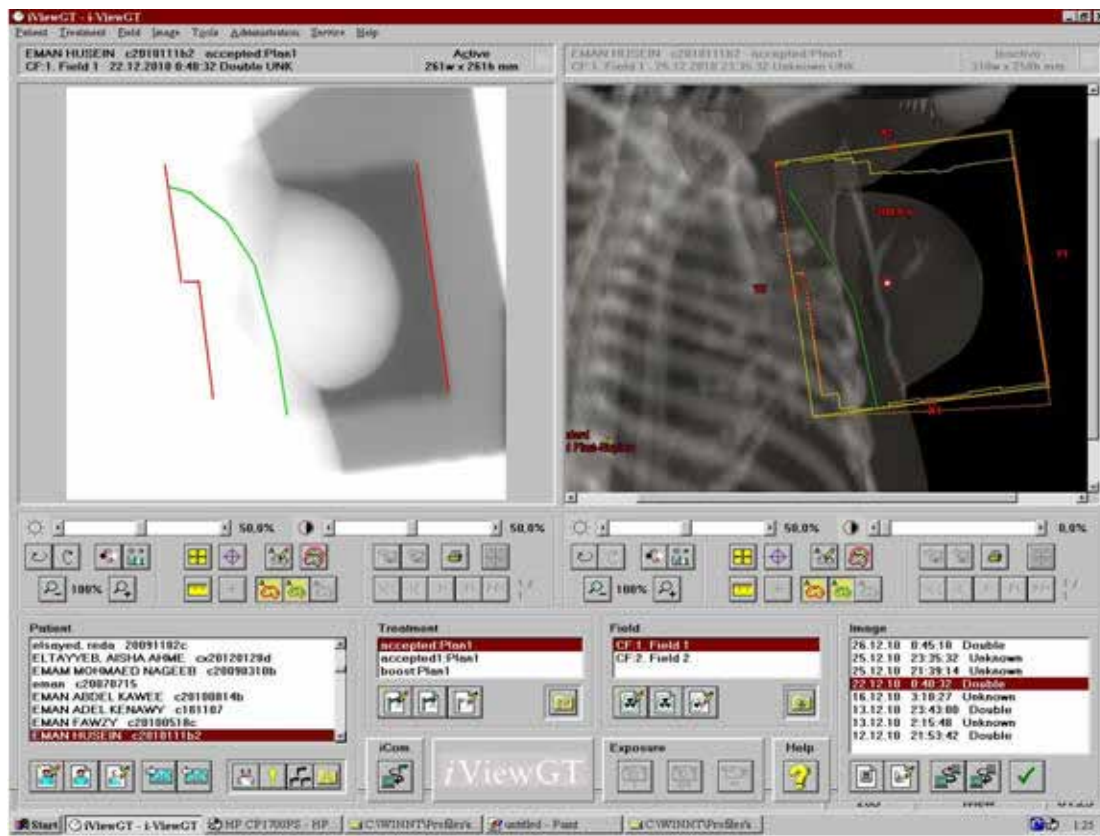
Comparison of Electronic Portal Image (EPI)to the left with Digitally Reconstructed Radiograph (DRR) to the right.
